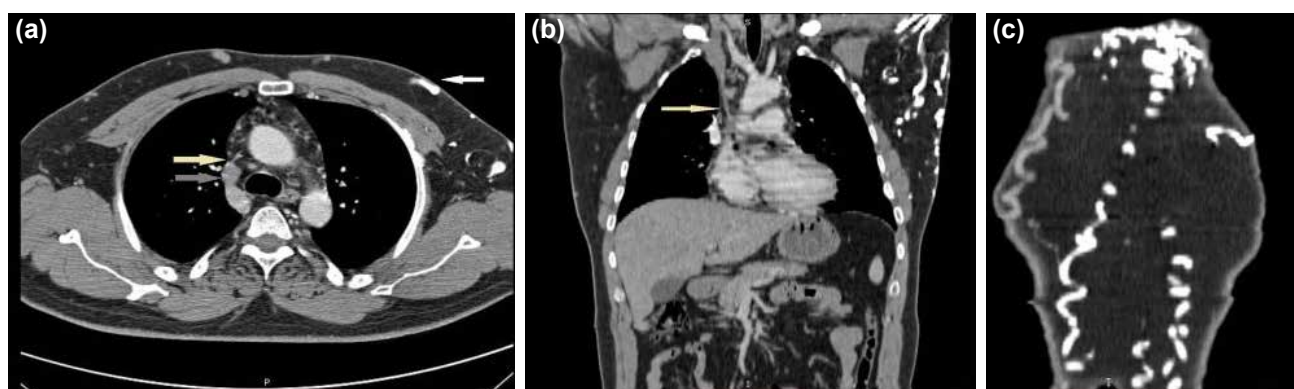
Contrast-enhanced computed tomography of the chest. (a) The obvious occlusion of the superior vena cava (SVC) (yellow arrow), with dilated azygos vein (grey arrow), and collateral veins on the chest wall (white arrow). (b) Coronal reformatted images indicating tight SVC occlusion (arrow) and (c) subcutaneous collateral veins on the chest and abdominal walls.
